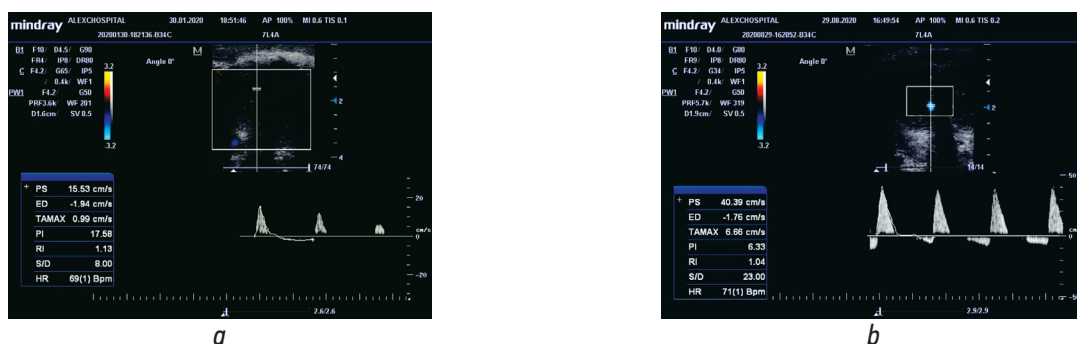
Doppler ultrasound of the vessels of the penis of patient V., 62 years old, BPH and arteriogenic erectile dysfunction. *a* – Before surgery: in the tumescence phase V_{max} (maximum systolic blood flow velocity) 15.5 cm/s, *RI* (resistance index) 1.13; IIEF-5 13 points; *b* – 24 weeks after laser enucleation of the prostate (HoLEP), in the tumescence phase V_{max} 40,4 cm/s, *RI* 1.04; IIEF-5 20 points
